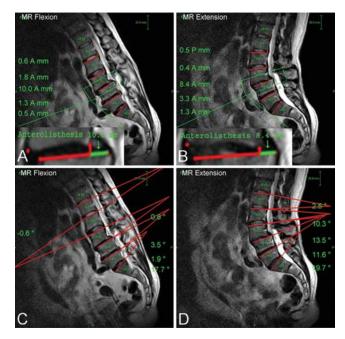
Examples of translational and angular motion from flexion to extension as measured by MR Analyzer computer-based software on sagittal MR images. A: Translational motion in flexion. B: Translational motion in extension. Total translational motion was calculated as the absolute value of the difference between flexion and extension. C: Angular motion in flexion. D: Angular motion in extension. Total angular motion was calculated as the absolute value of the difference between the angle between adjacent vertebral bodies in flexion and in extension in degrees. Tan et al: Kinetic magnetic resonance imaging analysis of lumbar segmental mobility in patients without significant spondylosis. Eur Spine J 21:2673–2679, 2012. Copyright Springer. Reproduced with kind permission from Springer Science and Business Media. Figure is available in color online only.
